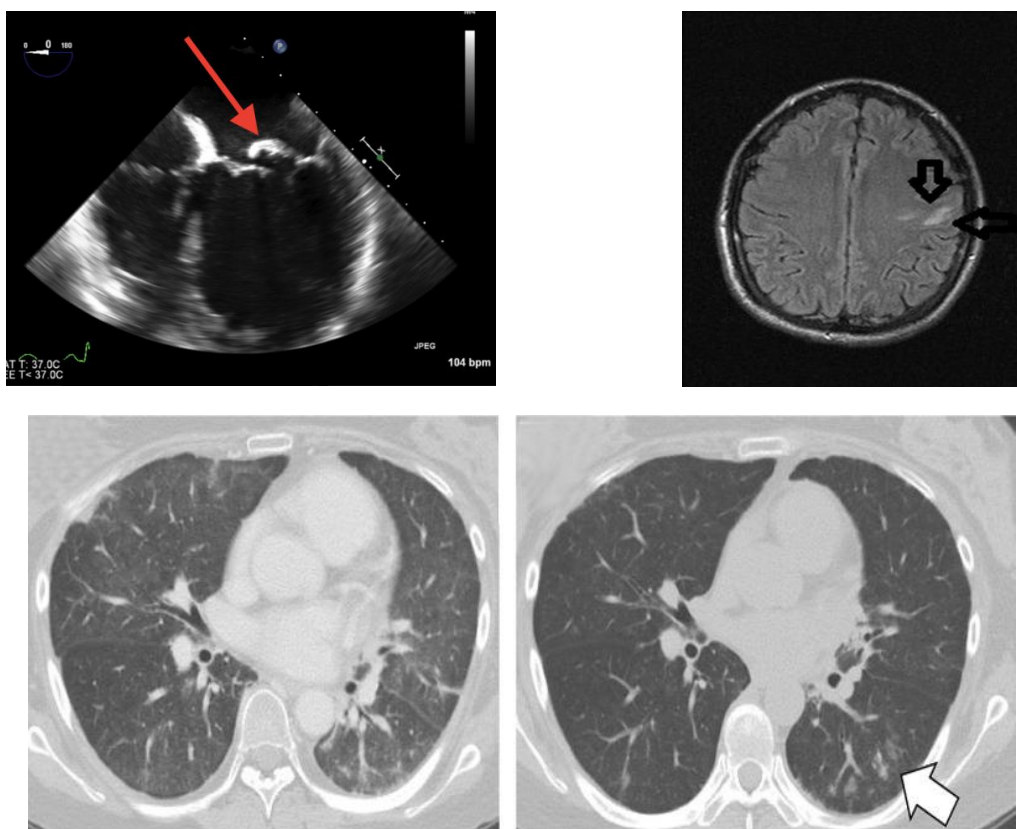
Male patient aged 55 years HTN, not DM, smoker with history of mitral valve prolapse presented with high grade fever 2days before admission. Chest examination shows bilateral crackles. Heard pansystolic murmur at mitral area. Abdominal examination shows splenomegaly. CT chest shows congestion with pneumonic patches. CT brain shows small parietal infarction
